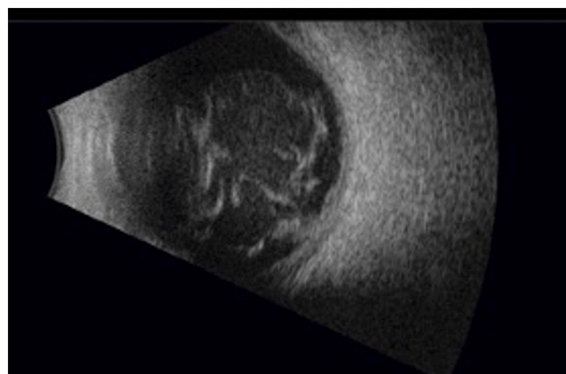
B-scan ultrasonography of the left eye showing aphakic eye with mild vitreous hemorrhage.
